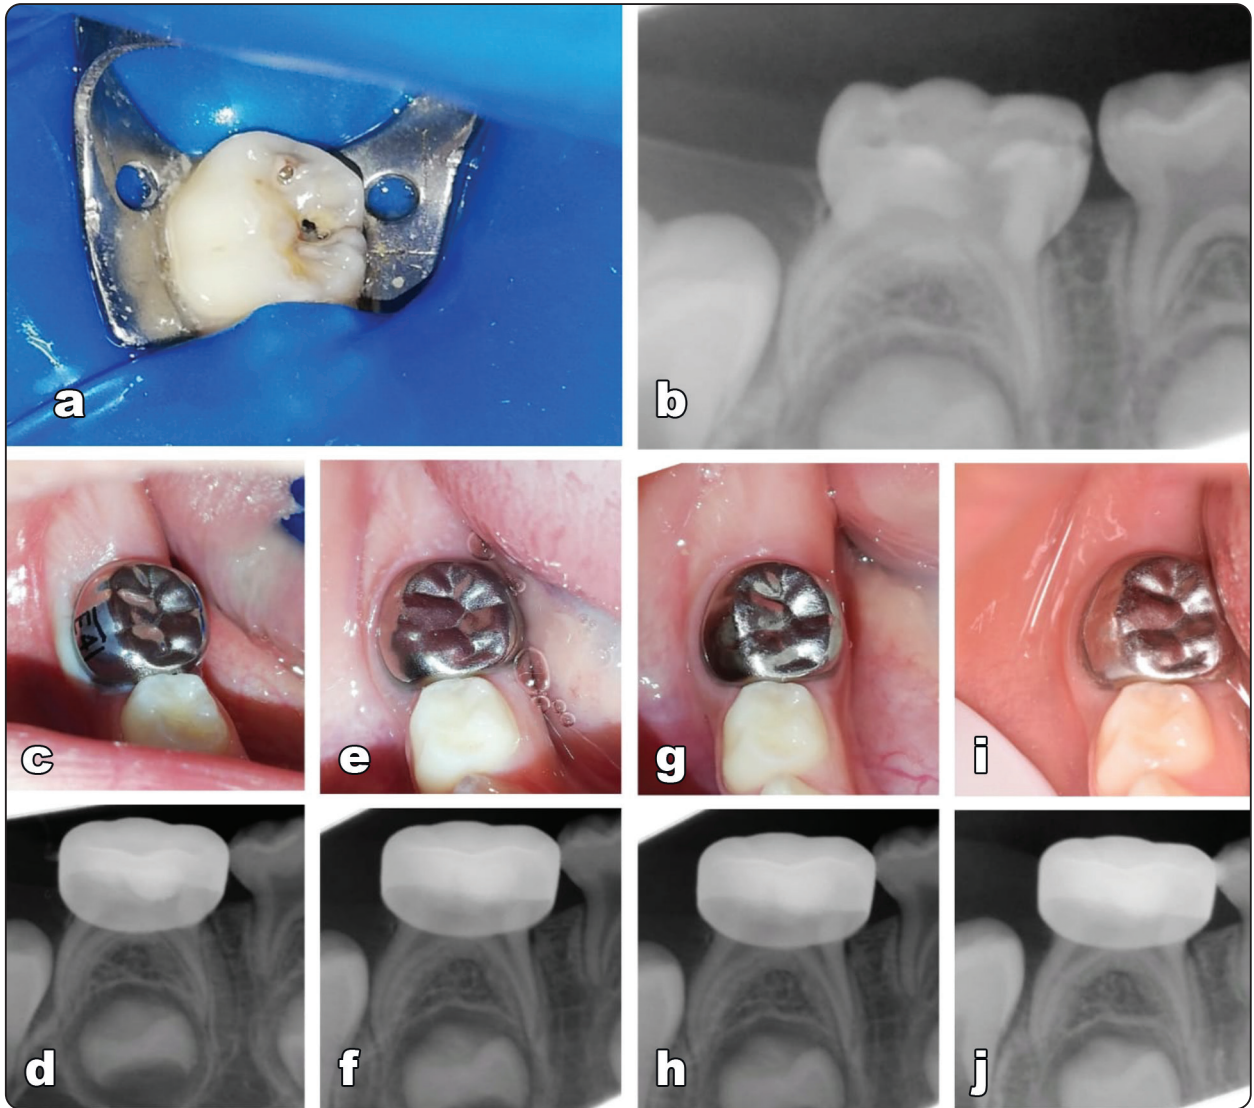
Clinical and radiographic assessment of DPC with MTA a and b: preoperative photo and radiograph, c and d: postoperative photo and radiograph, e and f: after 3 months , g and h: after 6 months , i and j: after 12 months
